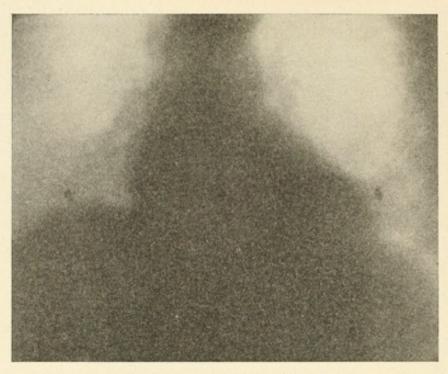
Before the resistance-exercises. (X-ray photograph of heart.)
